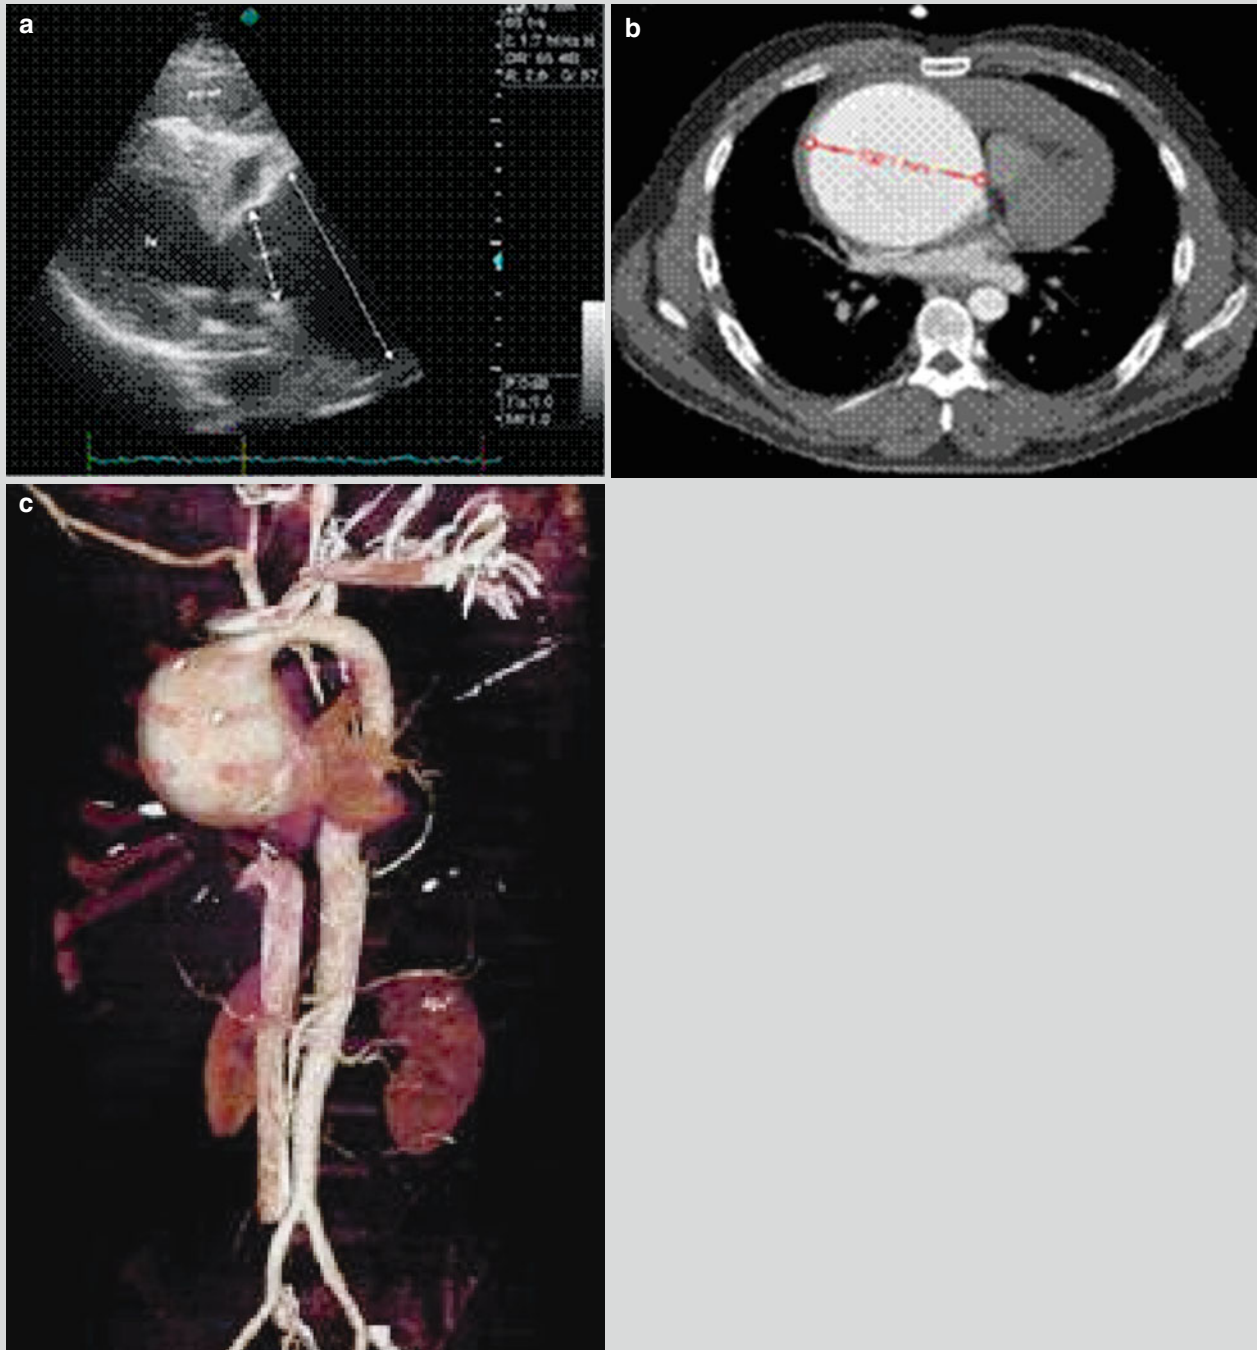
Syphilitic aortic aneurysm. (a) Ultrasonocardiography demonstrates serious dilation of the ascending aorta and accompanying moderate incomplete closure of aortic valve. (b, c) CT scanning
